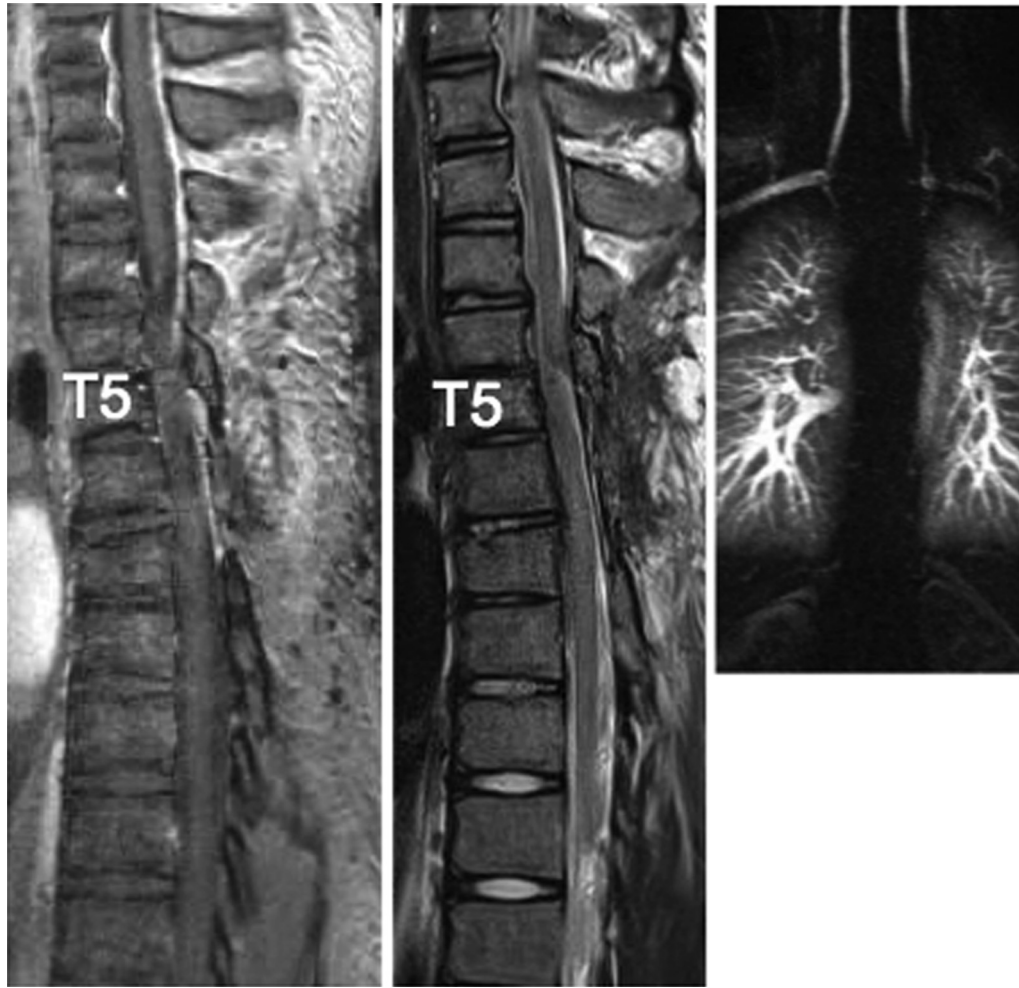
Magnetic resonance image of the lower cervical and thoracic spine 6 months postoperatively. (Left) T1-weighted gadolinium enhanced sagittal image showing disappearance of the epidural venous plexus. (Middle) T2-weighted sagittal image demonstrating a decompressed spinal cord. There was no T2 high-intensity area in the spinal cord. “T5” indicates (Left and Middle) the vertebral level. (Right) Magnetic resonance angiogram demonstrating no abnormality.
